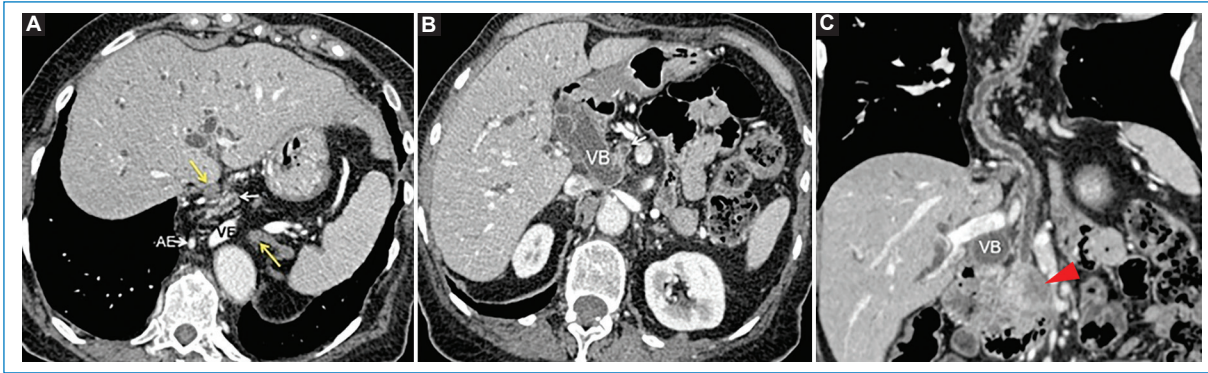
Type IV hiatal hernia. Axial slices (A and B) and coronal reconstruction (C) of a multidetector computed tomography of the thorax, abdomen and pelvis. Dilatation of the esophageal hiatus (yellow arrows) is observed with the gastroesophageal junction, stomach, pancreas (white arrows) and splenic vessels ascending into the thoracic cavity. The pancreas is seen to be atrophic in its ascending course through the esophageal hiatus, with dilatation of the main pancreatic duct secondary to the presence of a hypovascular mass in the head of the pancreas (red arrowhead) which also causes dilatation of the bile duct (B and C).
